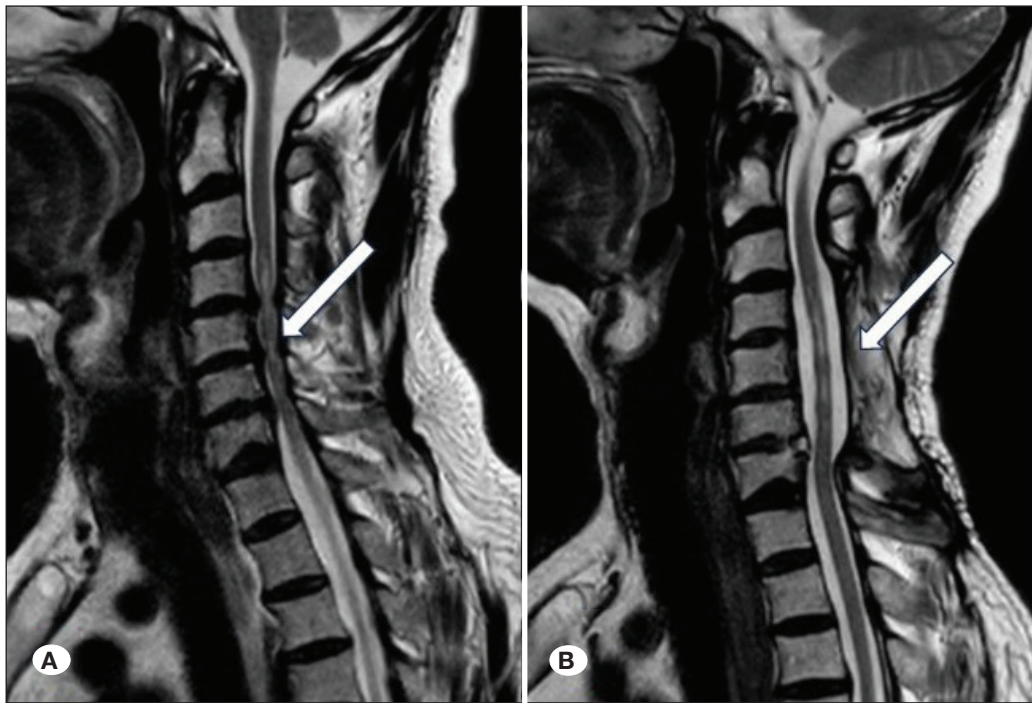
Example of ISI worsening in patient images. A) There was significant neural pressure at the C4–C7 level on MRI and slightly increased intensity in the medulla spinalis on preoperative cervical T2WI MRI. B) Following posterior decompression and fusion, the white arrow indicates an increase in intensity at the spinal cord on sagittal T2WI MRI.
